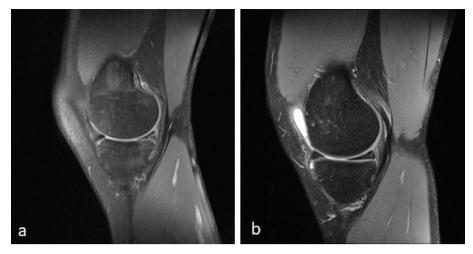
MRI left knee T2 sag a) vertical posterior horn medial meniscus tear b) one year postoperative meniscus still in place.
